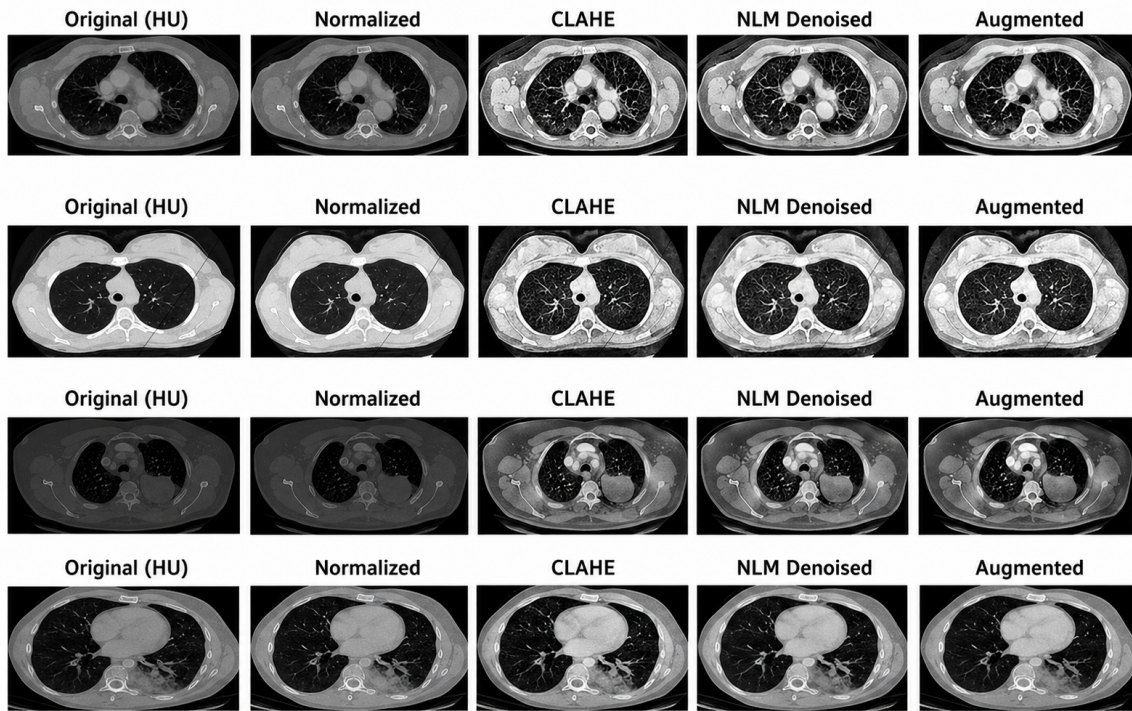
Preprocessed output for Chest CT images dataset
